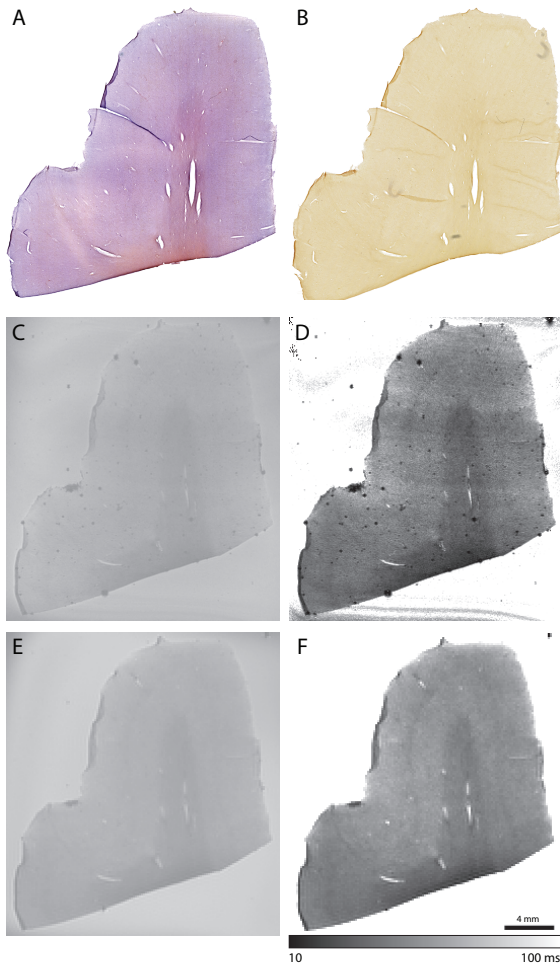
MRI characteristics of healthy age-matched brain tissue
